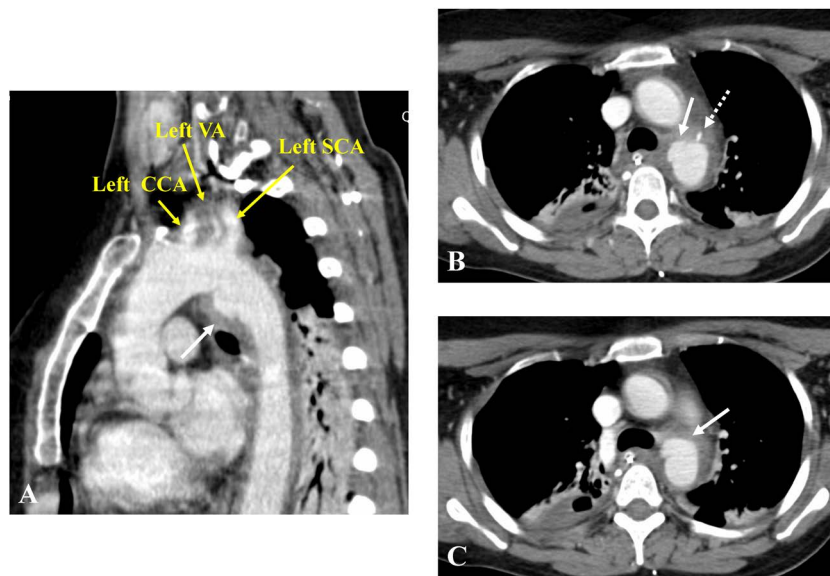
Computed tomography angiography before surgery.
